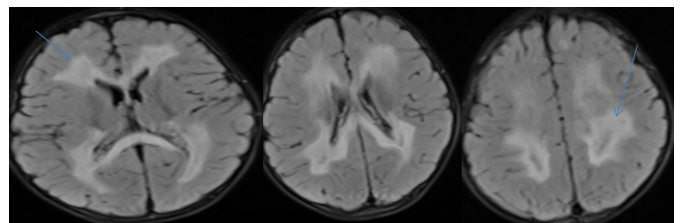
DWI axial images show confluent symmetrical hyperintense areas in the fronto-parietal white matter and corpus callosum
